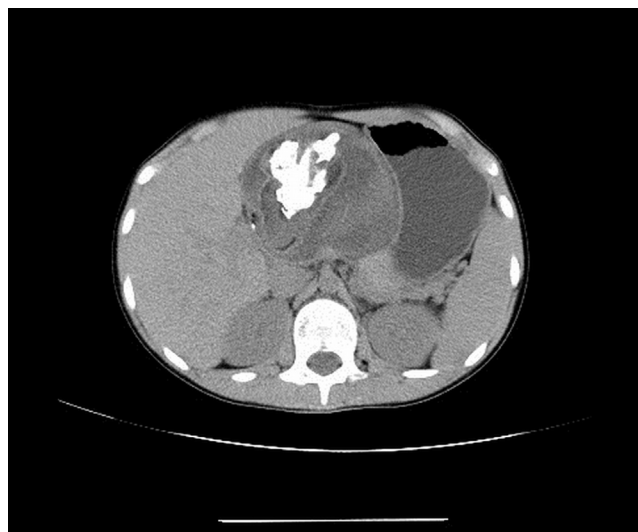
Well-defined mass with massive calcifications at CT exam.
